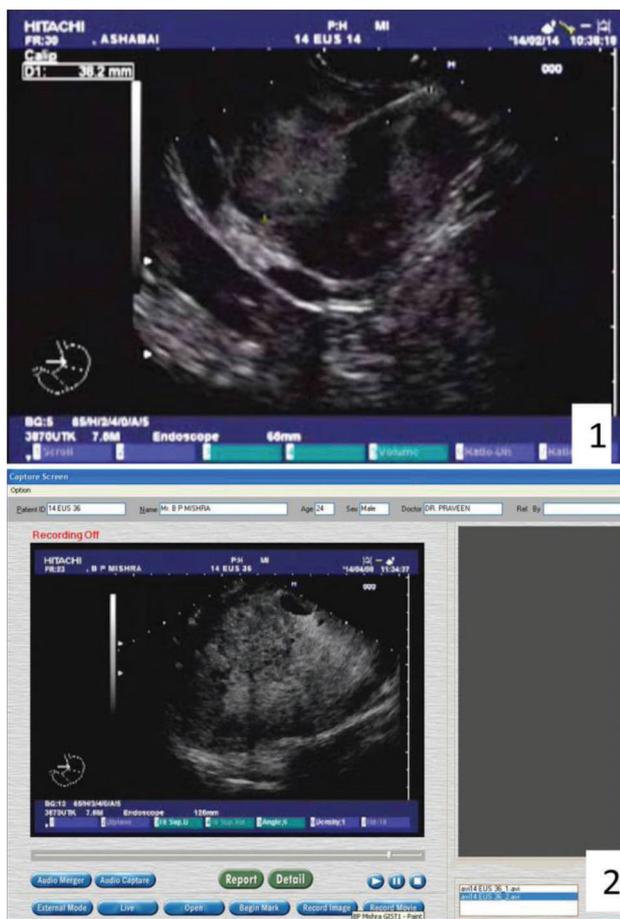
Endoscopic ultrasound findings
